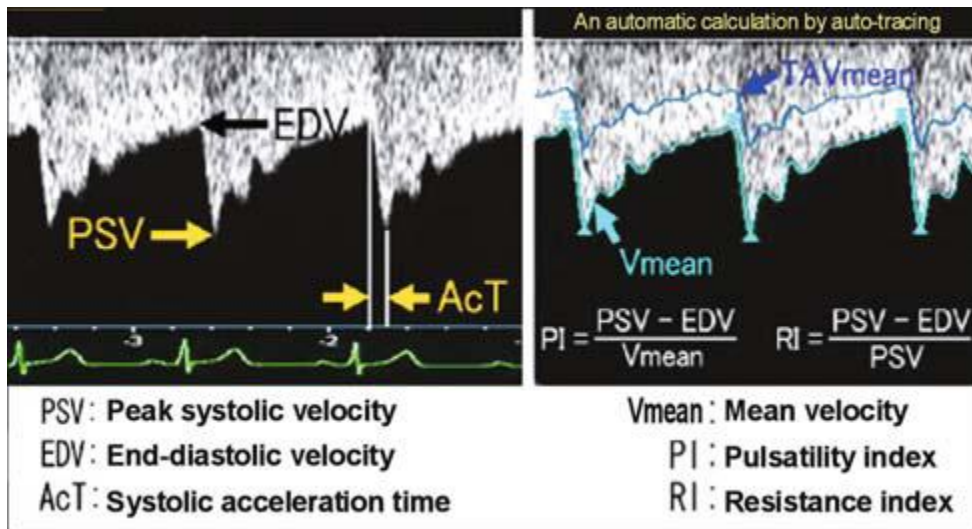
shows spectral Doppler display with calculated mean velocity (Zagzebski,1996).
